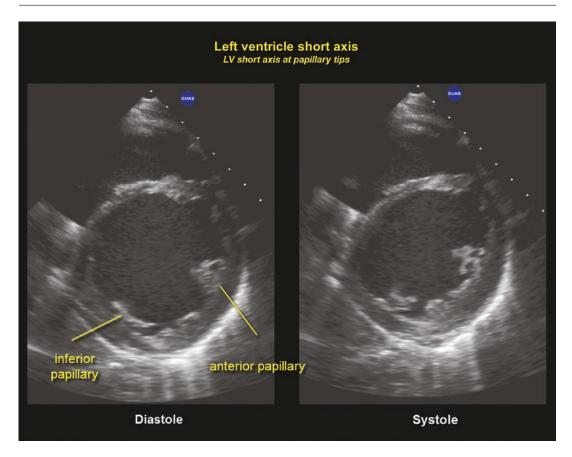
Parasternal short axis echo view from the chest wall at the level of the papillar bases in a patient with a dilated cardiomyopathy
